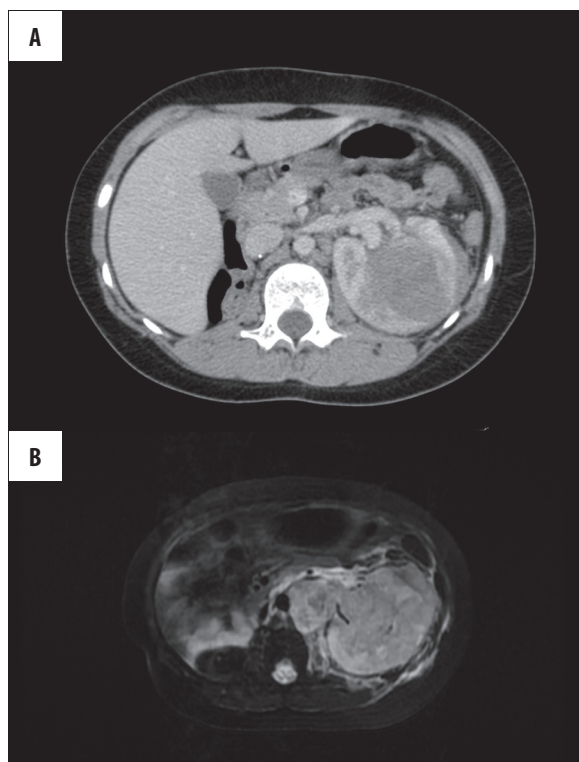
Patient MM age 8 with diagnosis of nephroblastoma post nephrectomy at the right side. MRI examination in T2 FatSat sequence shows another focus of the tumor in left kidney. Controlling CT shows acceleration of tumor size.
